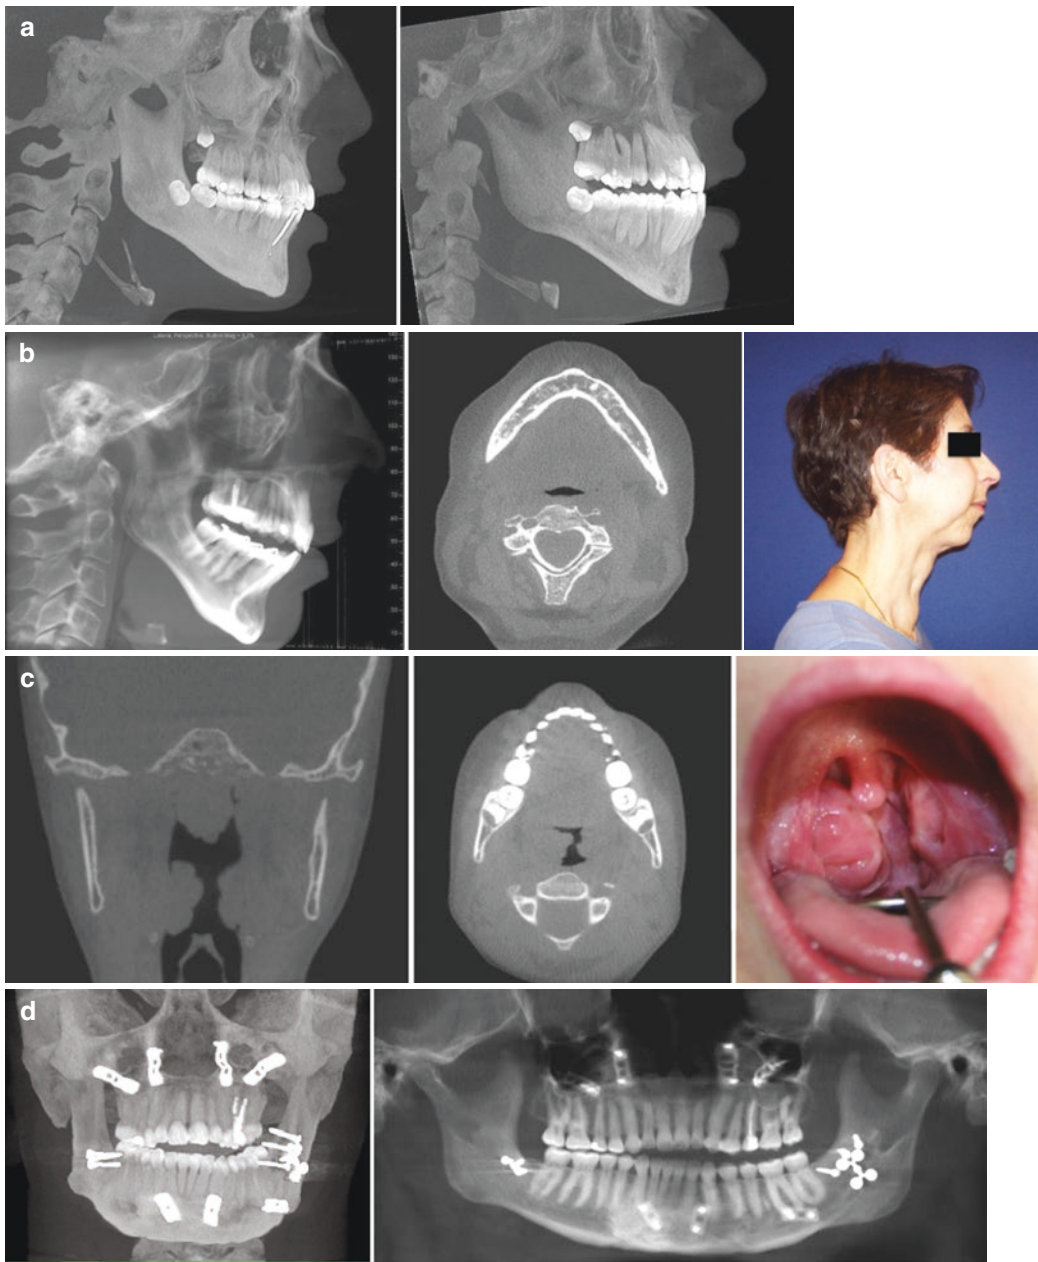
Airway Information as seen on CBCT (a) High horizontal mandibular angle. (b) Pharyngeal airway impingement. (c) Enlarged tonsils. (d) Previous orthognathic surgery
